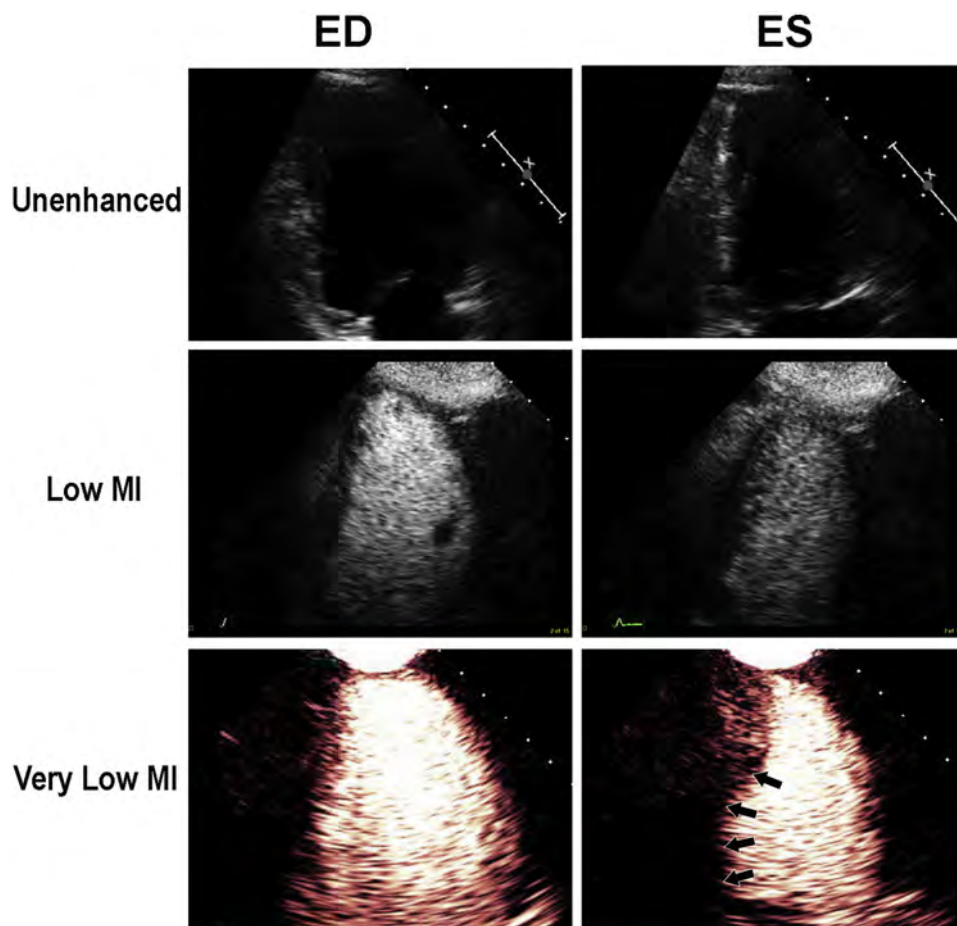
End-diastolic (ED; *left*), and end-systolic (ES; *right*) in the apical two-chamber view, demonstrating how only VLMI imaging with UEAs can completely delineate a basal to mid inferior wall thickening abnormality. Because VLMI imaging is done with power modulation, fundamental nonlinear responses are detected, resulting in less basal segment attenuation compared with low-MI imaging (*middle*) which are attenuated because they are harmonic frequency signals. See [Video 4](#), available at www.onlinejase.com.
